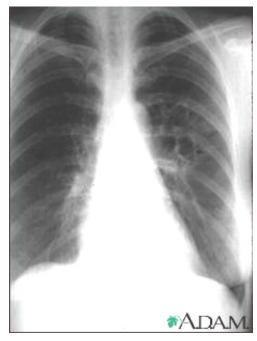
Chest x-ray showing effects of Valley Fever on the lungs
